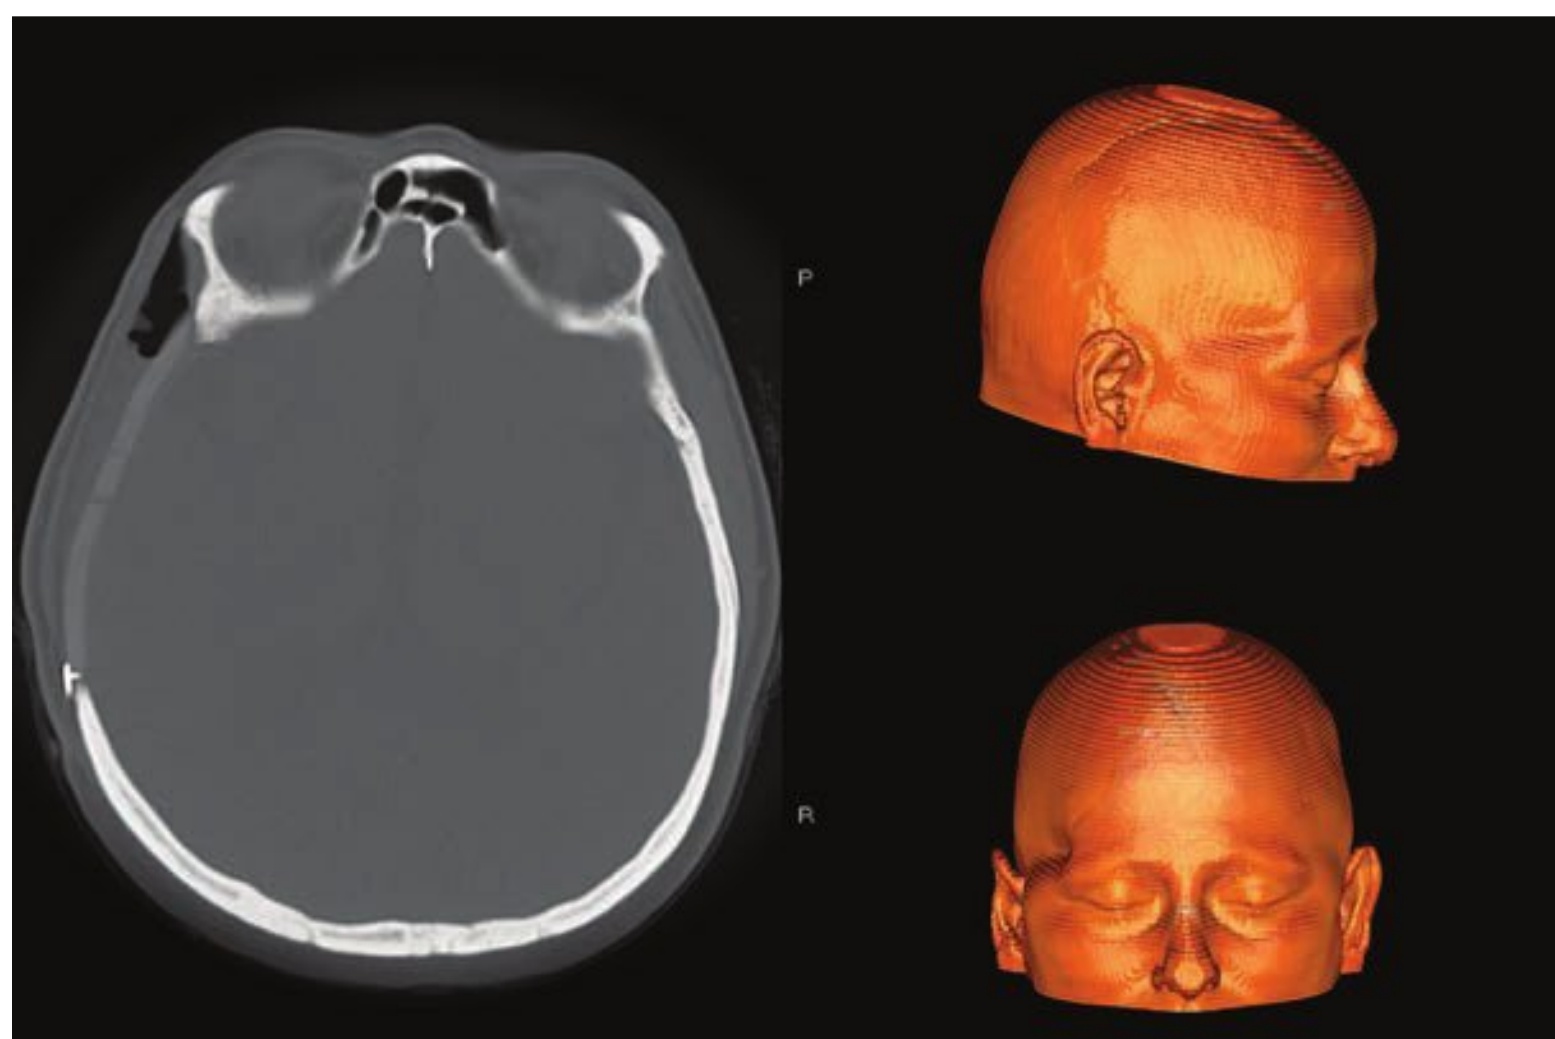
Three-dimensional CT rendering of preoperative soft tissue defect and axial CT image of porous polyethylene pterional implant (arrow).
